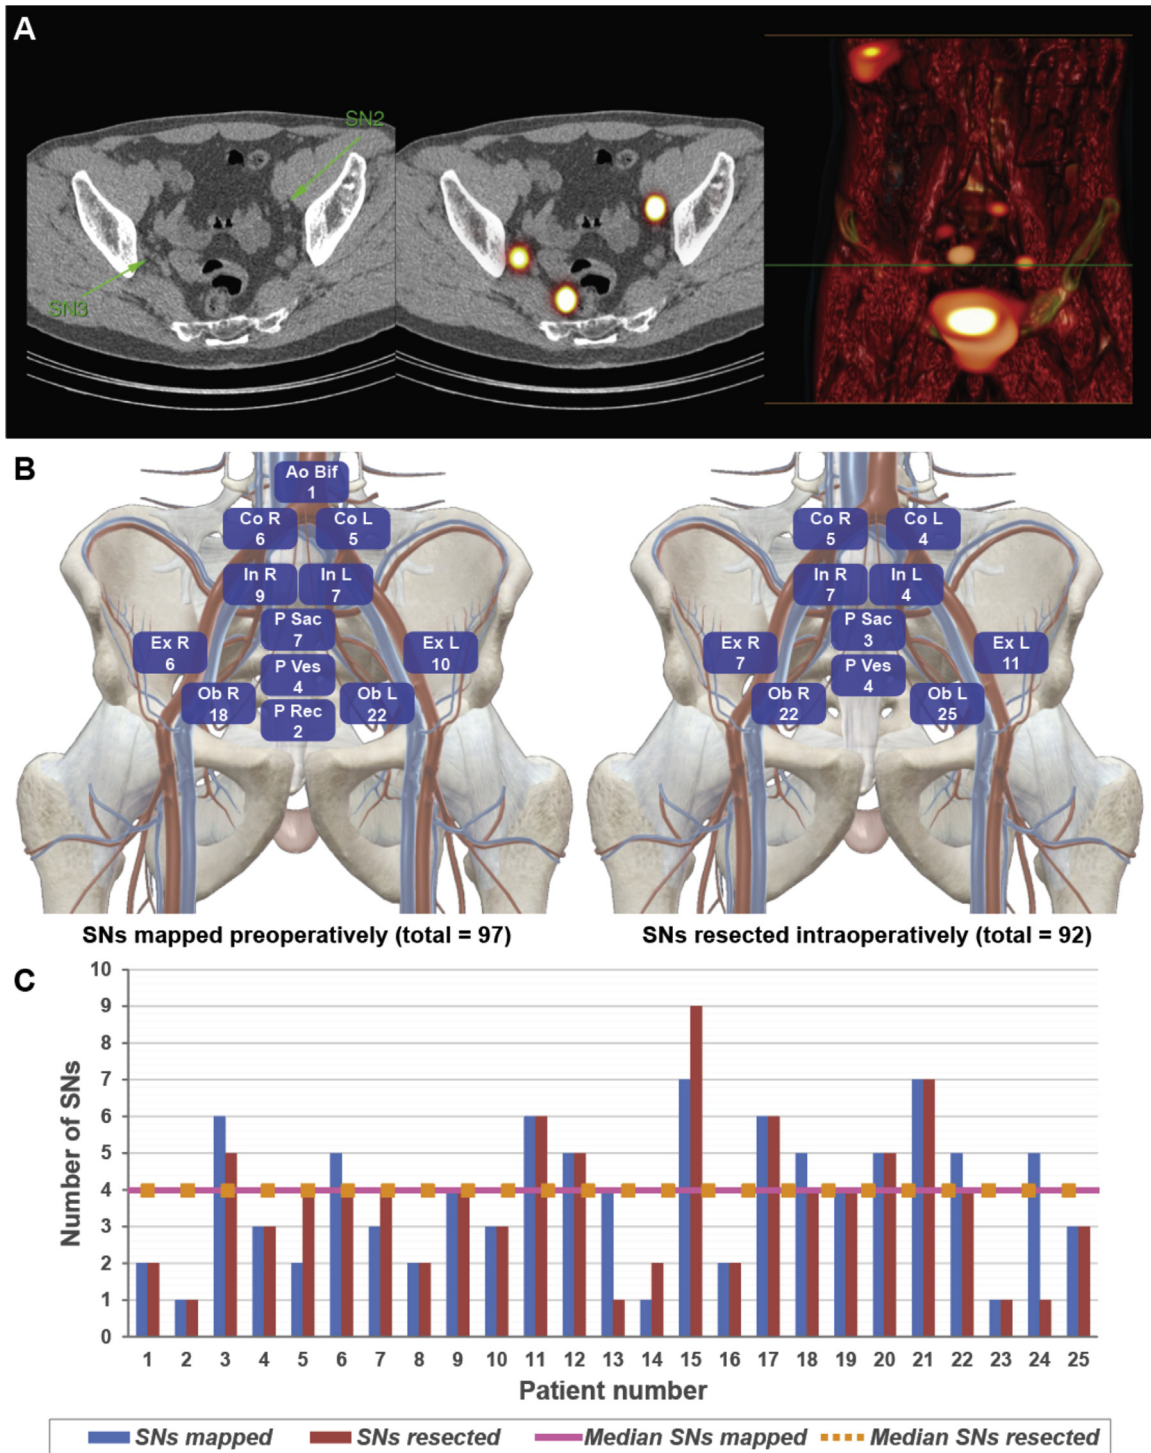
Preoperative mapping and intraoperative resection of the SNs: (A) SN mapping after either ^{99m}Tc-nanocolloid or ICG-^{99m}Tc-nanocolloid intraprostatic injection using single-photon emission computed tomography supplemented with computed tomography (SPECT/CT); SNs (B) mapped preoperatively and (C) resected intraoperatively according to anatomical location; (D) median of SNs mapped preoperatively and resected intraoperatively. Ao Bif= aortic bifurcation; Co = common; Ex = external; ICG = indocyanine green; In = internal; L = left; Ob = obturator; P rec = pararectal; P sac = presacral; P ves = paravesical; R = right; SN = sentinel node.
